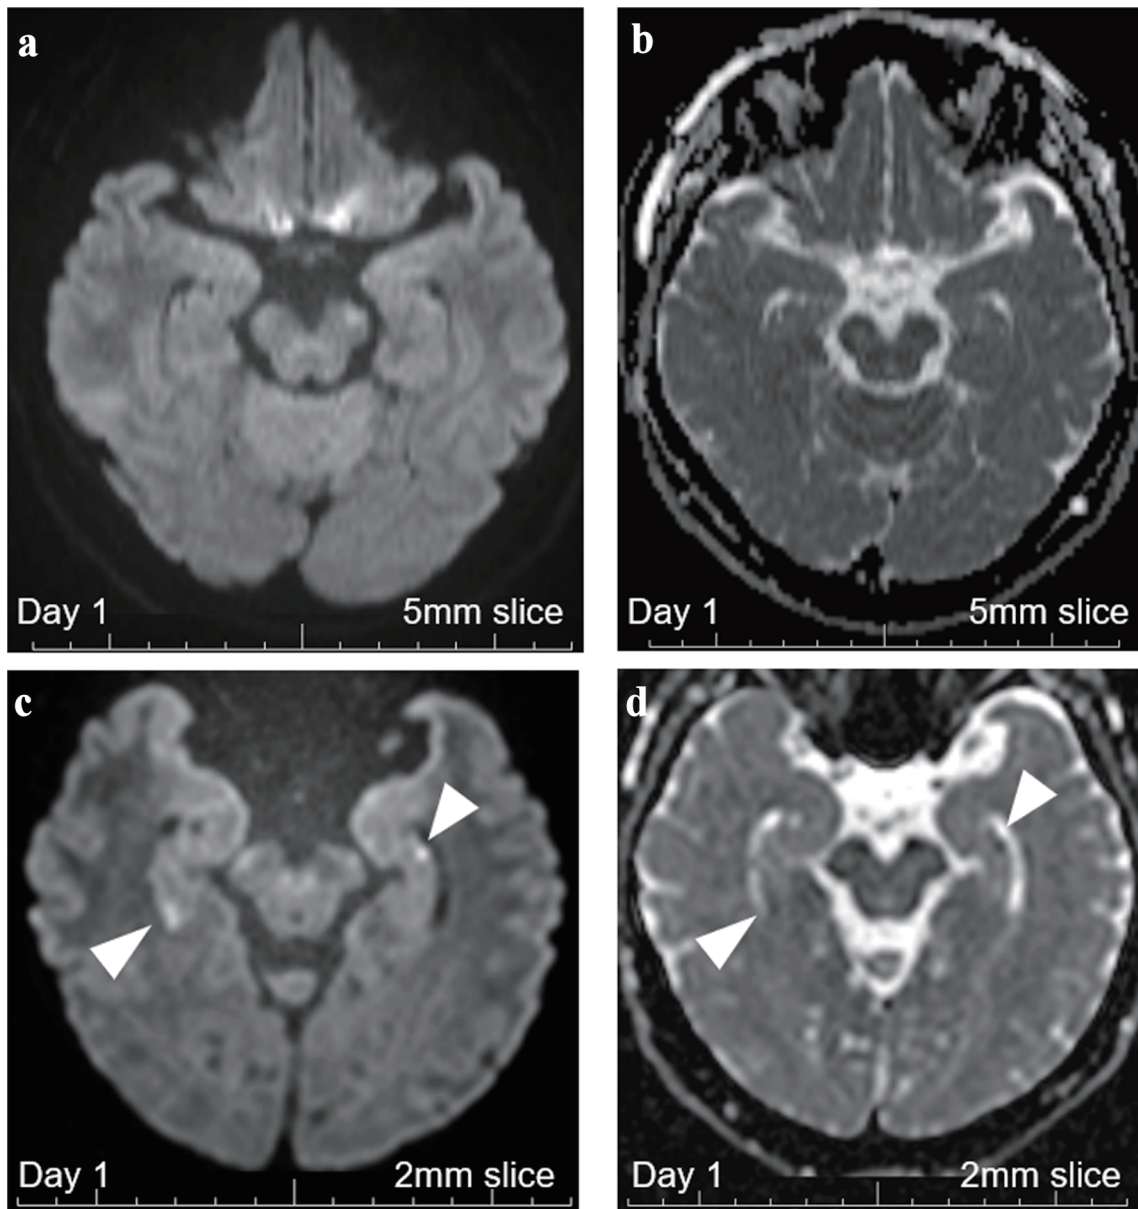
Brain MRI with 5-mm thickness and 2-mm thin-slice on day 1. (a) DWI with 5-mm-thick brain MRI on day 1 revealed no abnormalities. (b) ADC with 5-mm-thick brain MRI on day 1 revealed no abnormalities. (c) DWI with 2-mm thin-slice brain MRI on day 1 revealed two hippocampal signal high lesions each on both sides (white arrowheads). (d) ADC with 2-mm thin-slice brain MRI on day 1 revealed signal losses for the two DWI-high hippocampal lesions (white arrowheads). MRI: magnetic resonance imaging; ADC: apparent diffusion coefficient; DWI: diffusion-weighted imaging.
